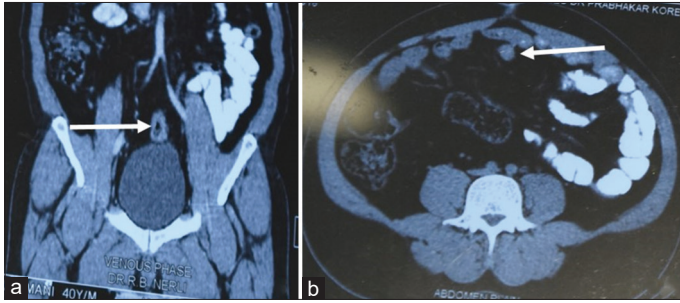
(a and b) Computed tomography scan shows evidence of a thin linear hypodense tract extending from the umbilicus toward the bladder of an approximate length of 4.5 cm
